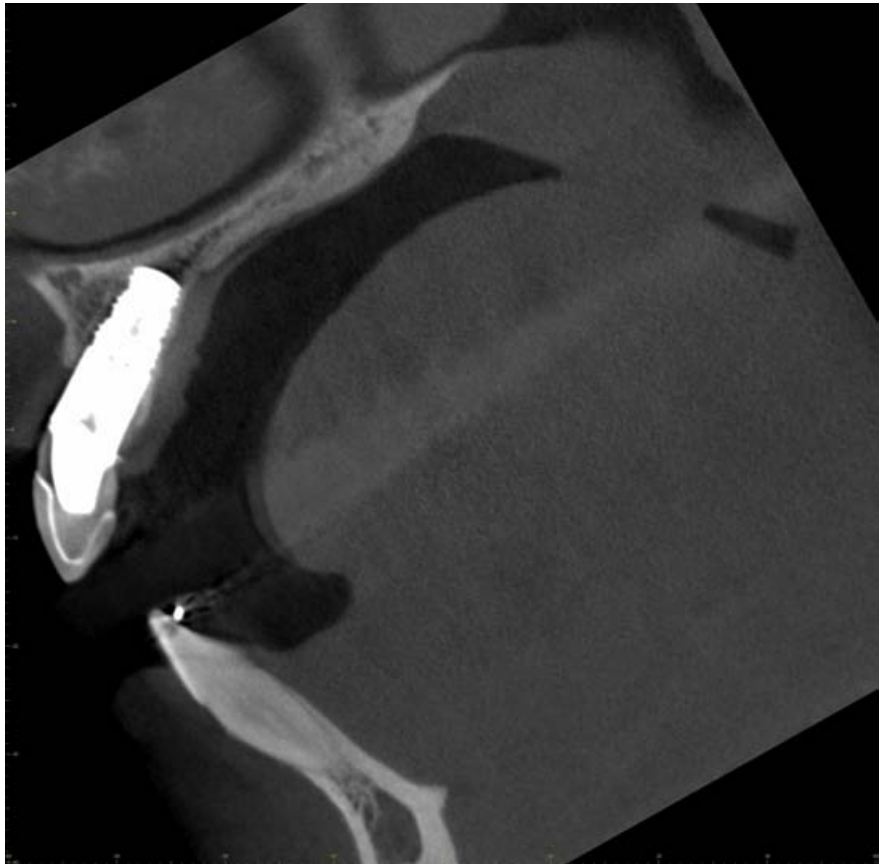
Sagittal CBCT slice
